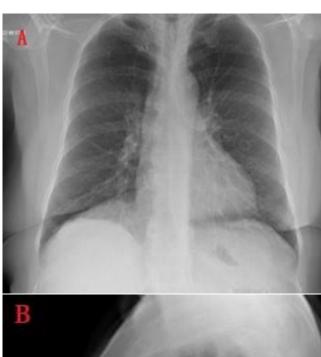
A sharply demarcated opacity in the lower lobe of the right lung was observed adjacent to the diaphragm on posteroanterior chest X-ray (a) and lateral chest X-ray (b)
